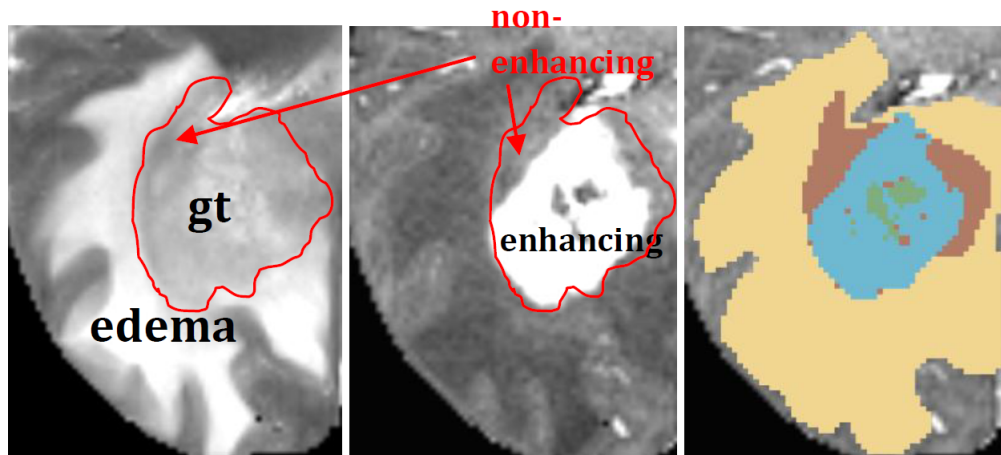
Definition of the label 3 for high grade glioma cases. Left: Gross tumor and edema regions are distinguishable on T2 images with different intensity and texture characteristics. Center: Enhancing tumor volume, which appears hyperintense on contrast enhanced T1 weighted MR images, do not completely overlap with gross tumor volume on T2-weighted images. Right: Corresponding labeling where the region that is not enhanced with the contrast agent but appears as a part of the gross tumor in T2 is labeled as non-enhancing in brown color (label 3).
